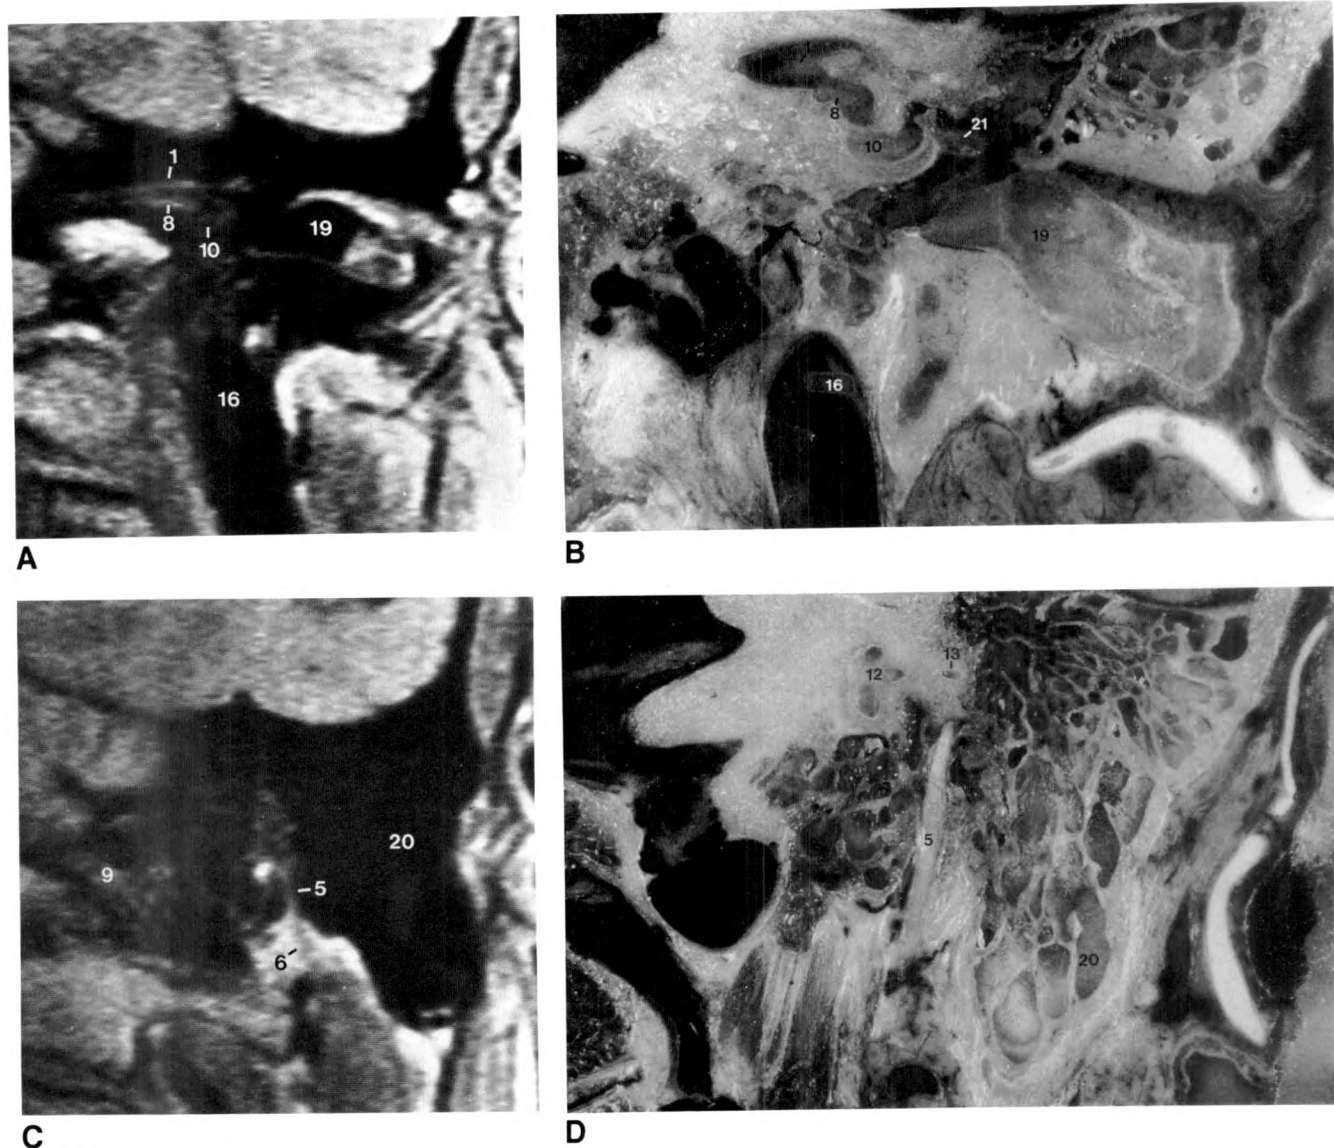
Coronal MR images and cryosections.
